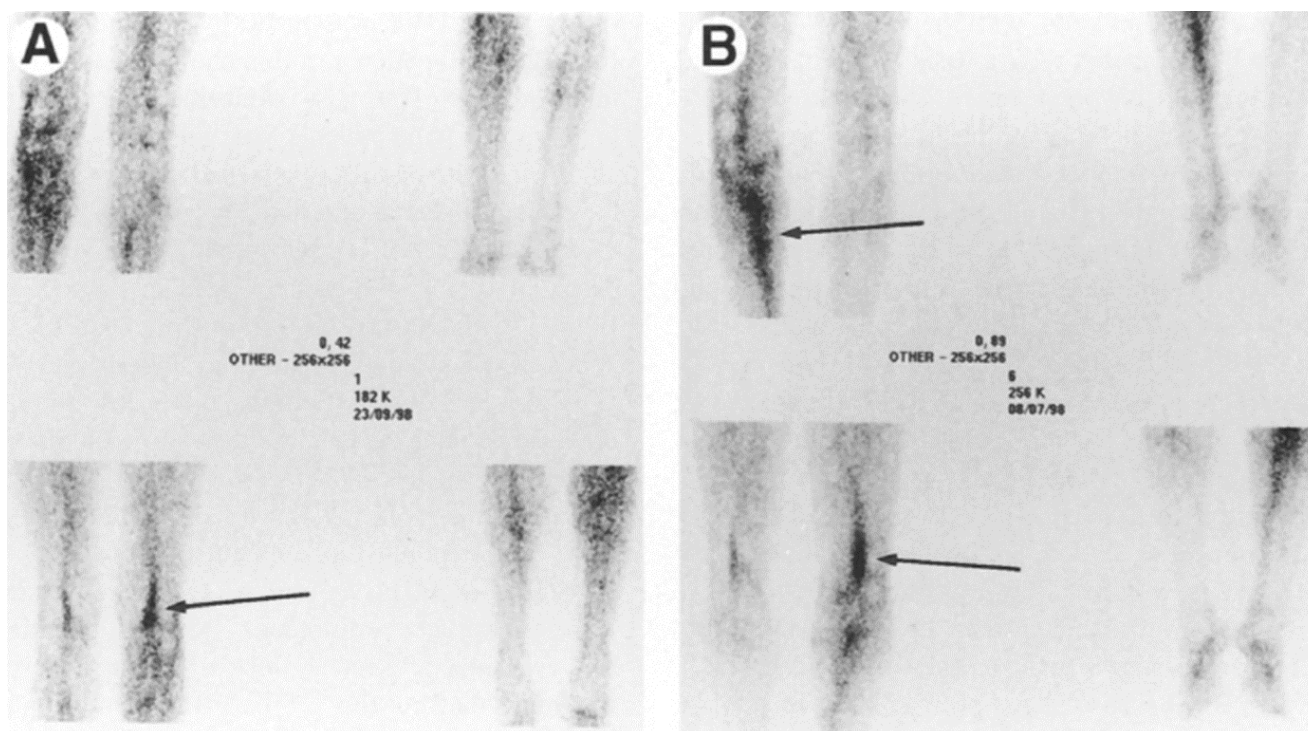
^{99m}Tc -FBD scintigraphs of 2 patients (A,B) obtained 2 h post injection, showing acute DVT of the right lower leg (arrows). Upper row = anterior view; bottom row = posterior view. Reprinted from Taillefer et al. with permission from Elsevier.¹⁹⁷
